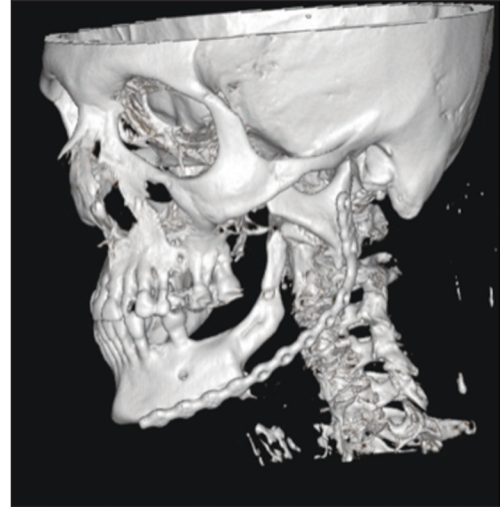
Bone regeneration in the operated area can be seen in the computed tomography image taken 3 years after the operation.
